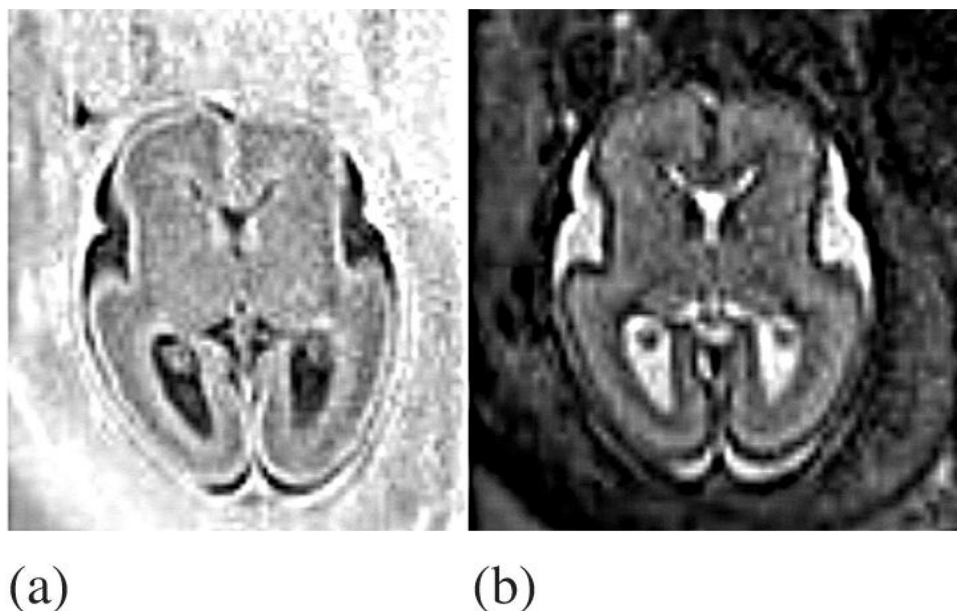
Snapshot inversion recover T-1 weighted (a) and T2 (b) weighted MRI images of the fetal brain in the transverse plane in a patient at high risk of preterm birth with premature rupture of the membranes at 24⁴ weeks gestation on a 1.5Tesla MRI scanner.
